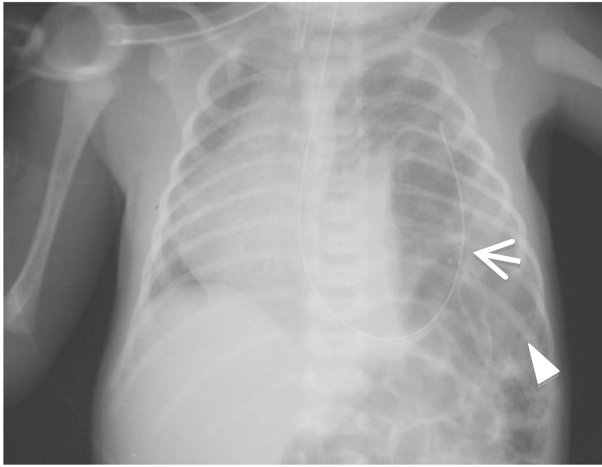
Chest radiograph in a baby which shows bubbly lucencies in the left thorax in keeping with bowel loops (arrowhead). This is a left sided congenital diaphragmatic hernia. The nasogastric tube is in the thorax (arrow) instead of its expected position below the diaphragm
